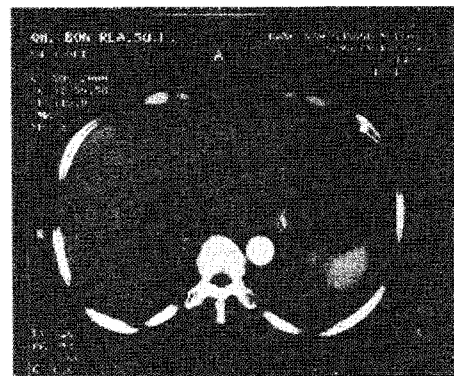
2001. 11. 1. CT in abdomen
